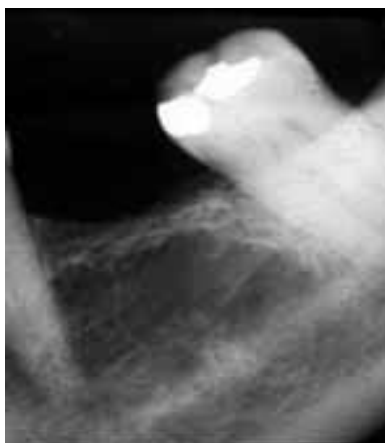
Periapical radiology of a patient with osteoporotic bone marrow defect [23].
